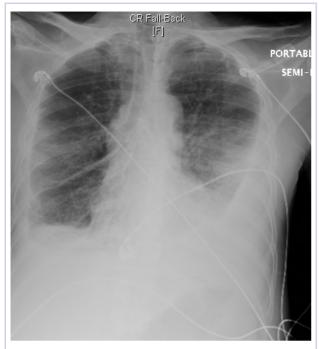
Chest X-ray showing bilateral pleural effusion blunting the costophrenic angles.
